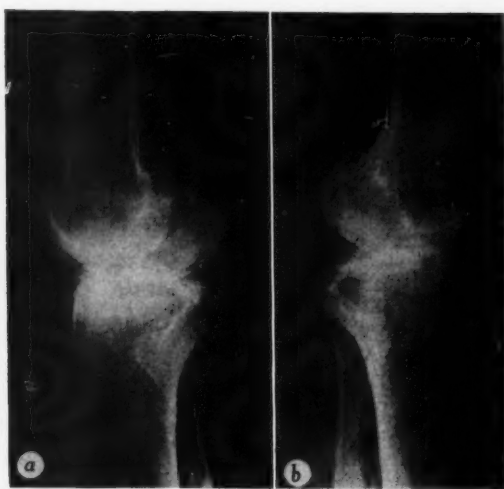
Lateral postoperative roentgenograms of *a*, right and, *b*, left knees of patient represented in Figure 4. Patellae excised.
